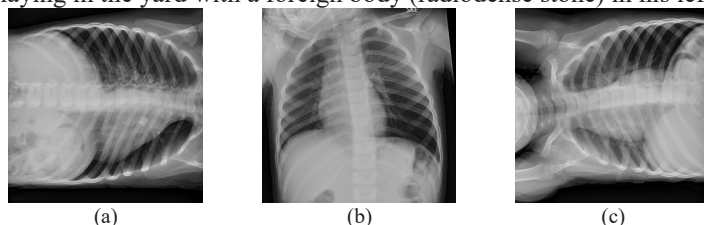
X-ray of the patient; (a) left lateral, (b) supine, (c) right lateral.
